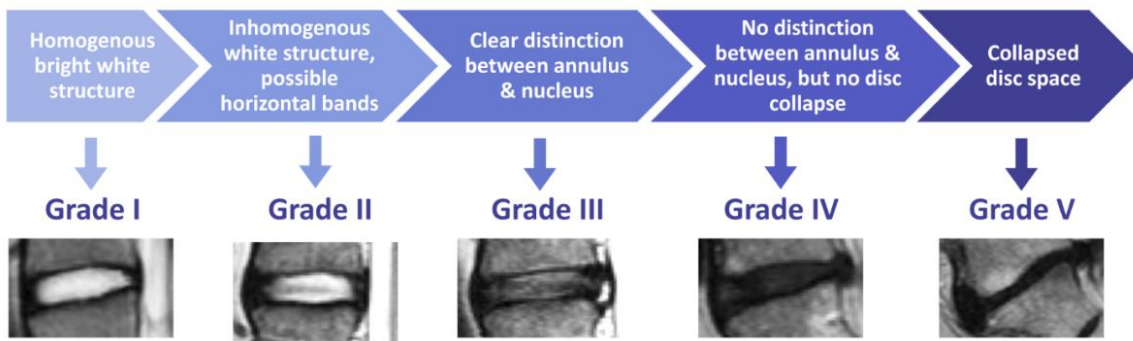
Evaluation of the lumbar spine using MRI and the radiological Pfirrmann grade, adapted from Lootus et al. (2014)⁶⁷
